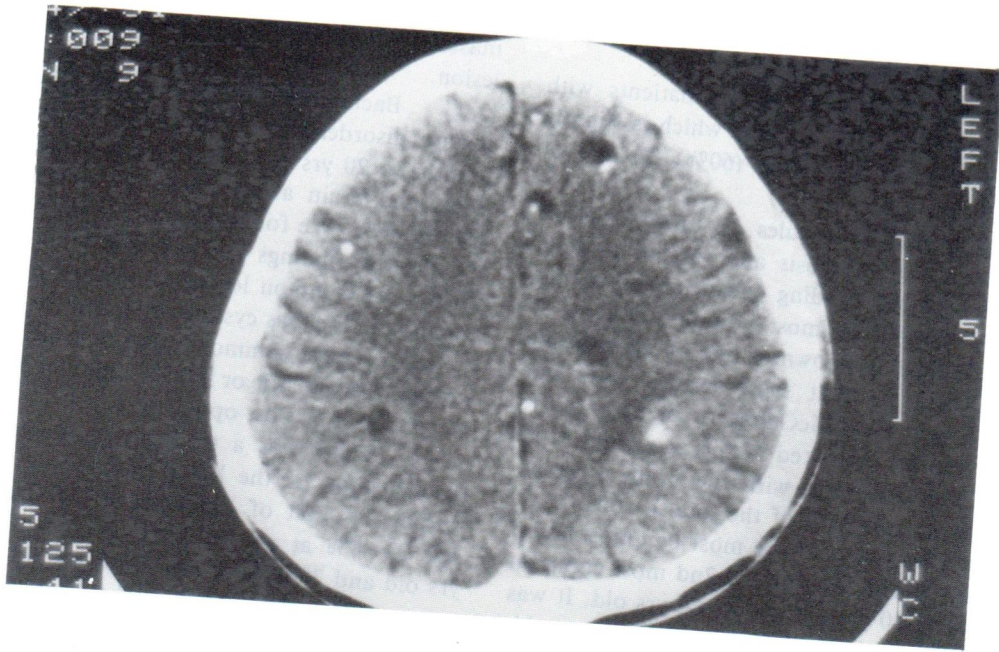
Cysticercosis. Non i.v. enhanced CT scan of the brain, supraventricular level showed small calcified nodules, small cystic lesions with and without calcified scolex at both frontoparietal lobes.
